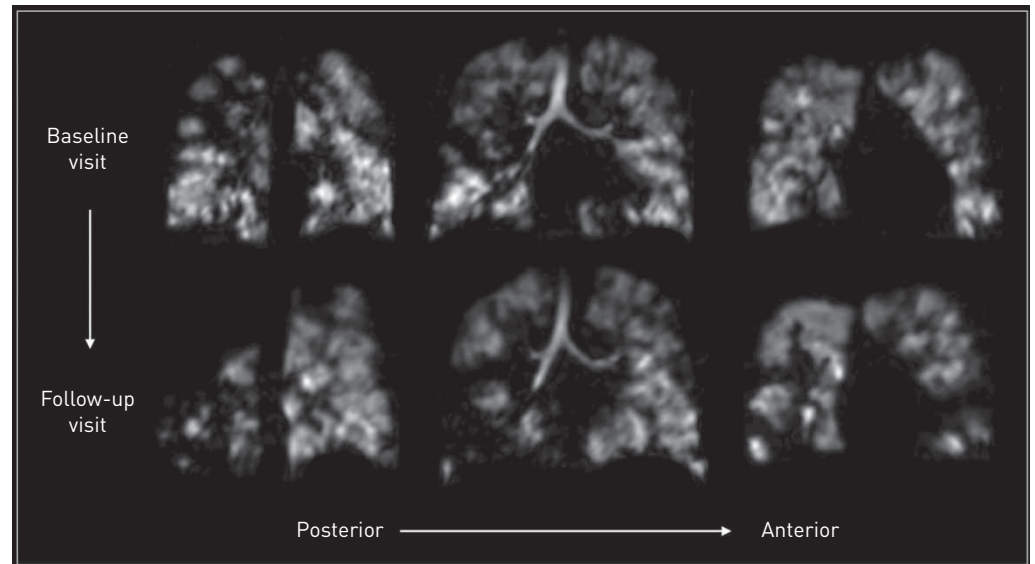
Longitudinal xenon-129 magnetic resonance imaging in a patient with abnormal forced expiratory volume in 1 s (FEV_1). This patient had a large and significant worsening in ventilation abnormalities over time, reflected by an increase in ventilation defect percentage (VDP) from 16.6% to 27.3%. Despite these ventilation changes, the FEV_1 z-score change was from -4.0 to -4.4 and the LCI change was from 12.9 to 13.6. In more advanced lung disease, as with this example, ventilation imaging can provide a detailed assessment of longitudinal change in lung function that conventional metrics are not sensitive to detect.
